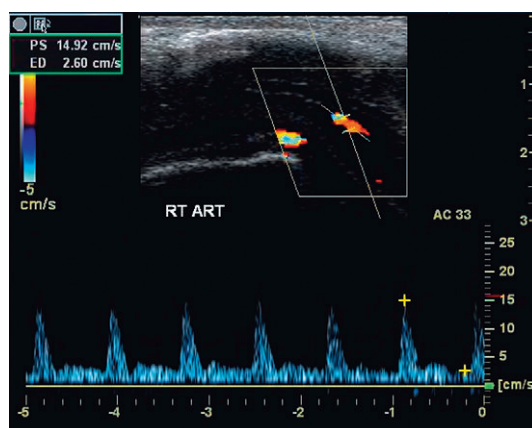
Spectral Doppler tracing in a patient with arterial insufficiency. Despite appropriate pharmaceutical dose, erectile response was suboptimal. Peak systolic velocity in a cavernosal artery only approximates 15 cm s^{-1} . This is well below the accepted range of normal.
